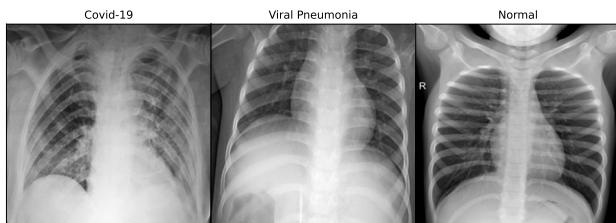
Sample images of Chest X-rays.
